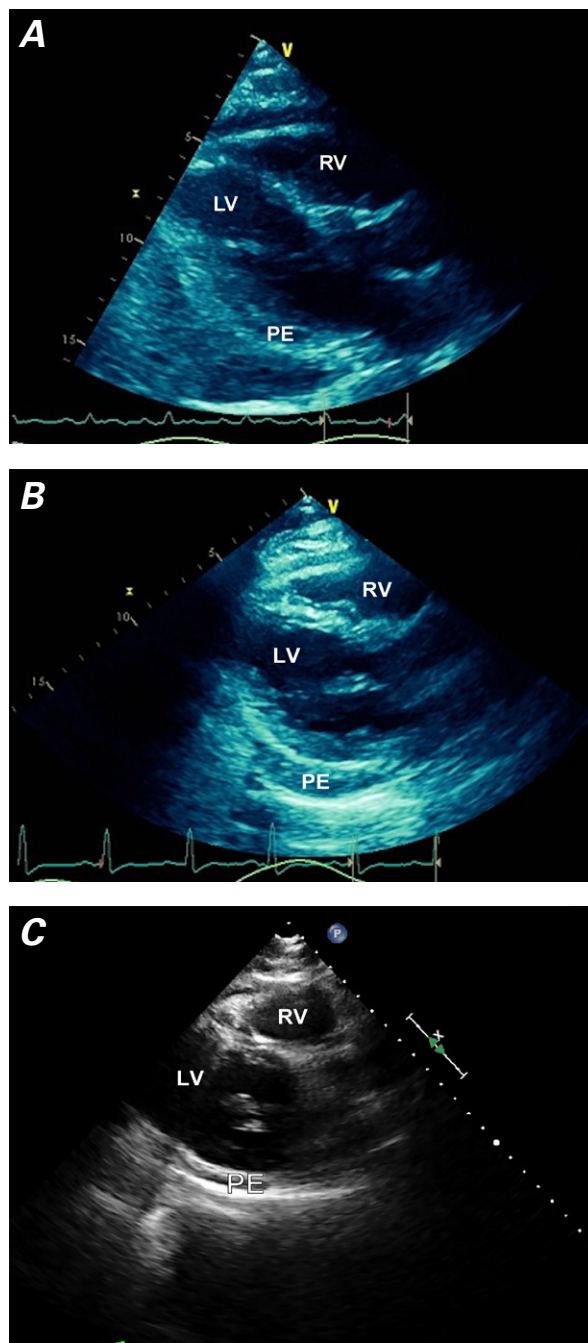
Transthoracic echocardiograms (parasternal long-axis views) show A) thickened pericardium with pericardial and left pleural effusions on admission, B) fibrinous material within the pericardial effusion on hospital day 3, and C) substantial resolution of the pericardial effusion after 3 weeks of medical therapy.
